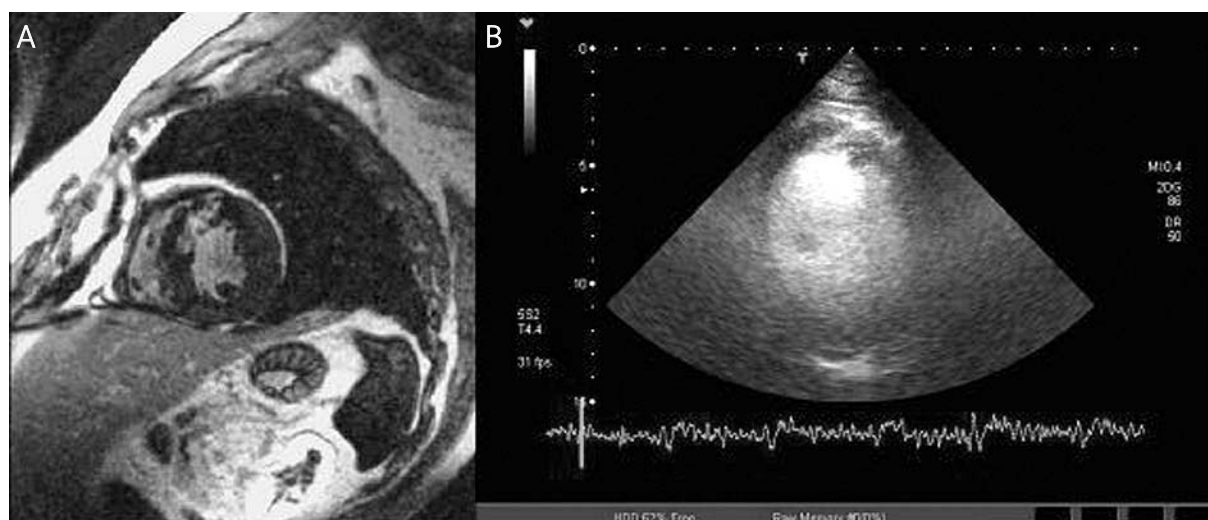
Short axis view in patient on third day after PCI. A – CE-MRI: late enhancement in interventricular septum, B – MCE perfusion defect in the same region
